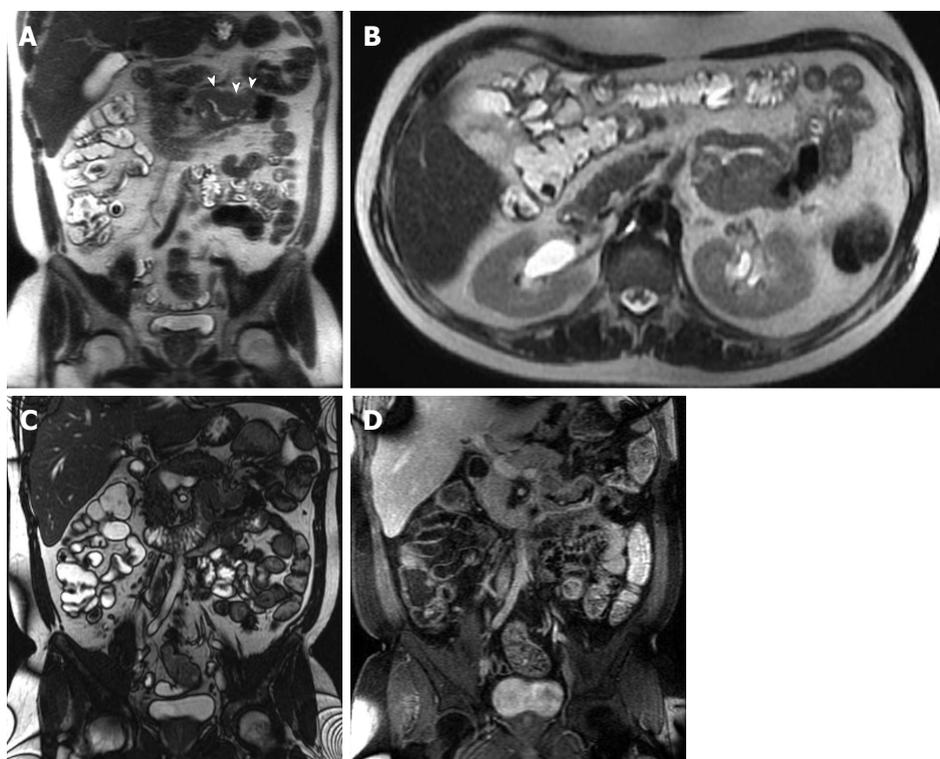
Jejunal lymphoma. A: Coronal and (B) axial T2-weighted single shot fast spin echo, (C) coronal balanced steady state free precession, and (D) coronal fat-suppressed post-gadolinium 3D-GRE T1-weighted images. There is a short segment of proximal jejunal circumferential, irregular, asymmetric wall thickening resulting in luminal narrowing (arrowheads, A) and demonstrates and intermediate T2 signal (A and B) and mild enhancement post-gadolinium (D) in keeping with a pathologically proven jejunal lymphoma. GRE: Gradient recalled echo.
